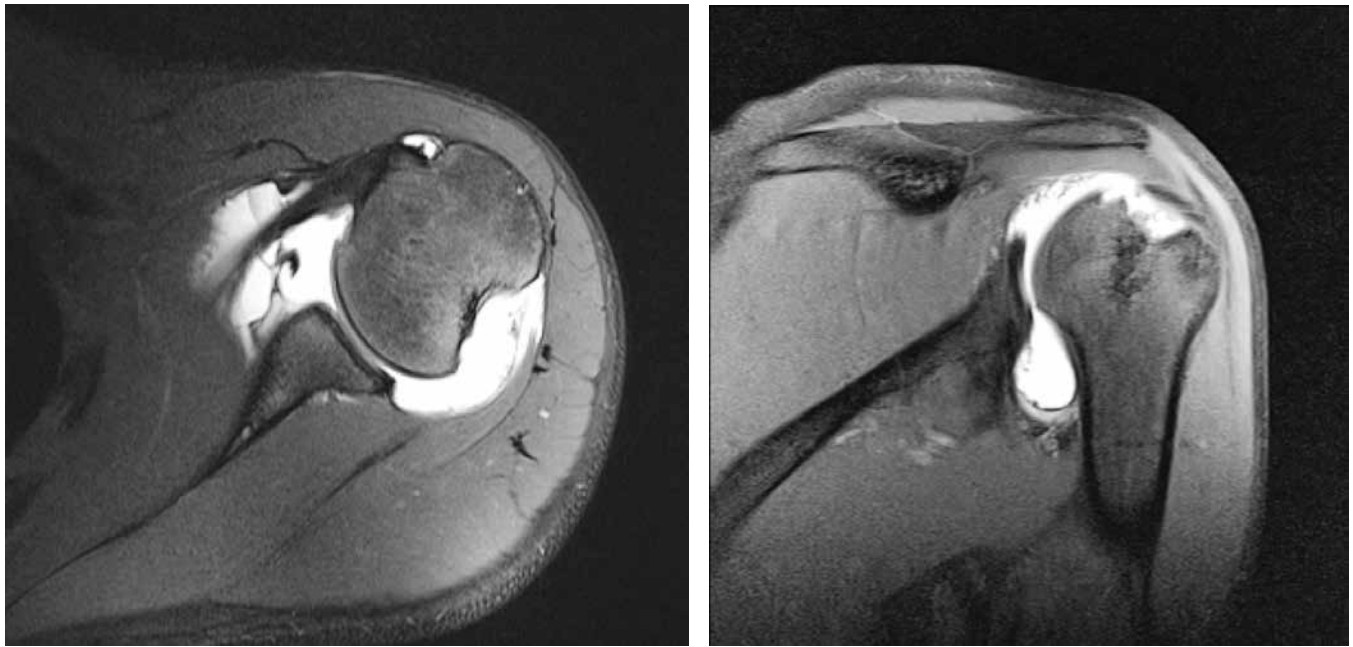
Magnetic Resonance Imaging of a loss of the anterior and inferior glenoid labrum and a Hill-Sachs lesion in the left shoulder.
